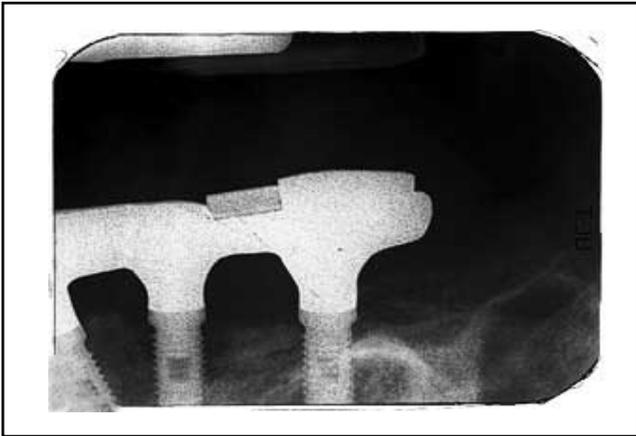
Case 2, periapical radiograph taken before implant retrieval.
